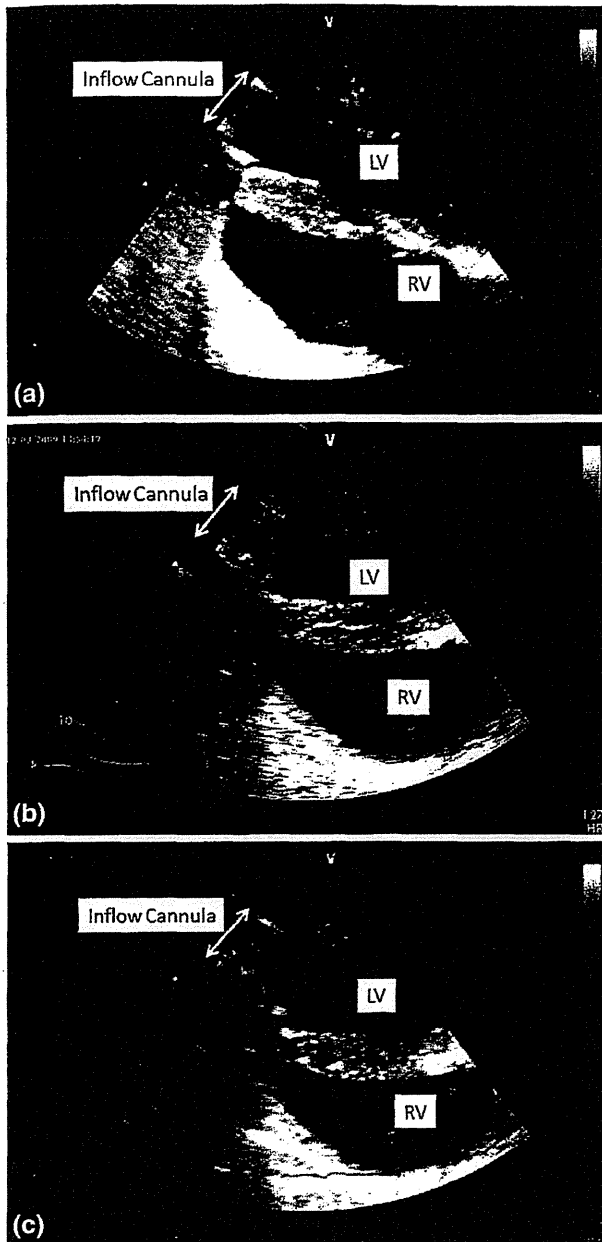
Echocardiography of the end-diastolic phase (a continuous mode, b counter-pulse mode, c co-pulse mode). The size of the left ventricle was significantly reduced in the counter-pulse mode (b) and increased in the co-pulse mode (c) compared with that in the continuous mode (a)
